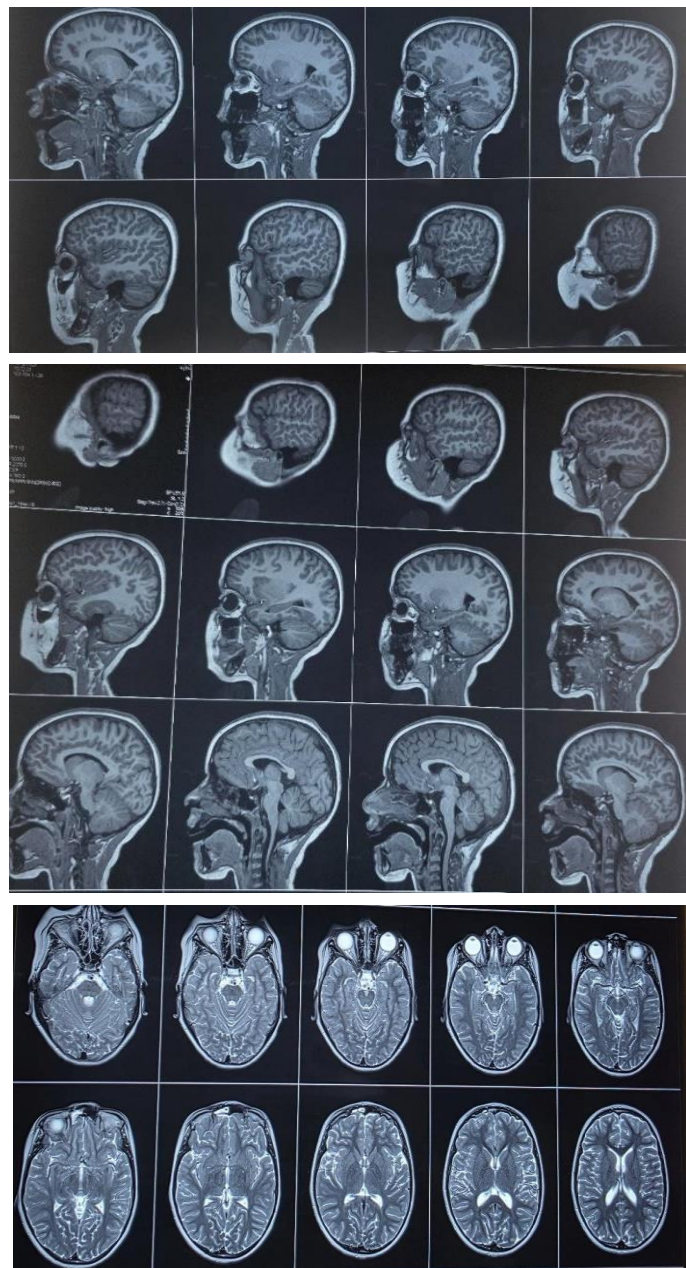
Brain MRI revealing dysmorphia of the foot of the third frontal gyrus (F3), bilateral and more pronounced on the left (Broca's area) with no other associated abnormality
